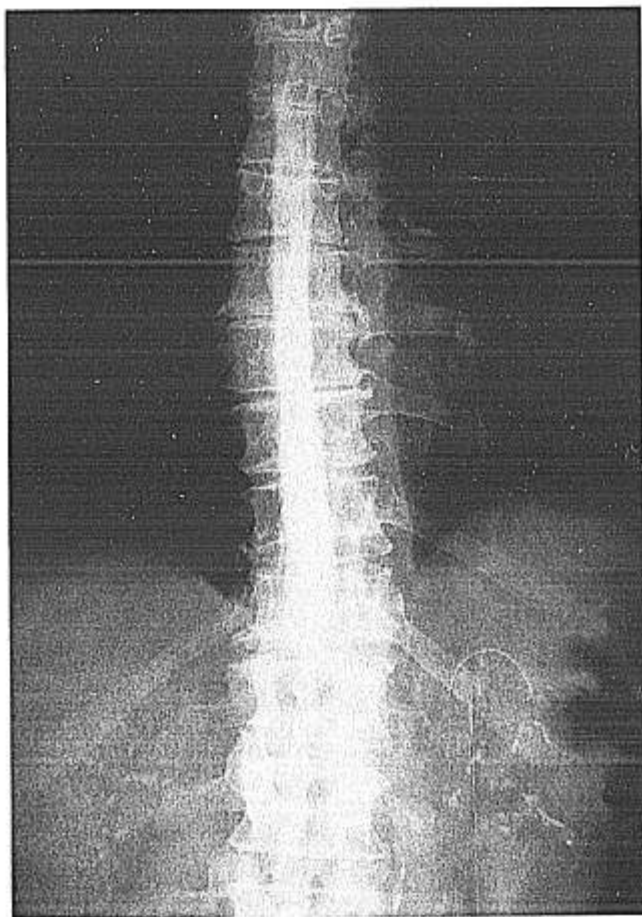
Radiography after injection of the hypertonic solution of the contrast media through the reservoir of the implantable device showing the subarachnoid space and the renal opacification.
